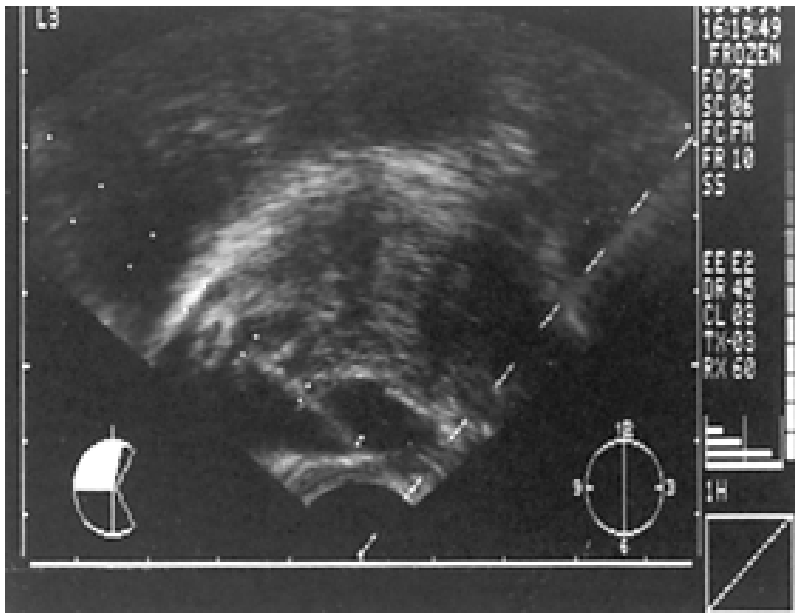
44. Sagittal image with biopsy guide with visualization of hyperechoic needle demonstrating the use of ultrasound guidance to assist in a biopsy.
